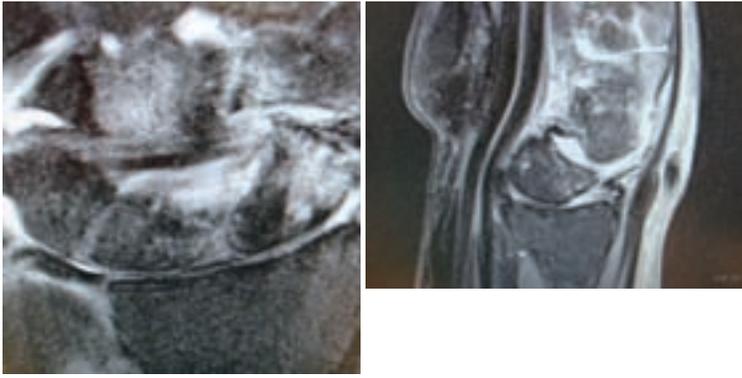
a and b. MRI of the wrist demonstrating tear of the scapholunate ligament, bone edema in the distal scaphoid and capitate, as well as DISI deformity.
